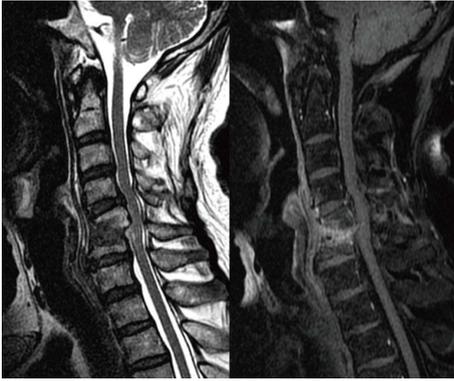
Sagittal T2-weighted and contrast-enhanced magnetic resonance imaging revealed C5-C6 infectious spondylitis with epidural abscess accumulation and spinal cord compression.
